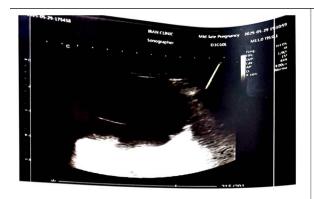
Abdominal sonography showing cystic lesion located in upper abdomen.
